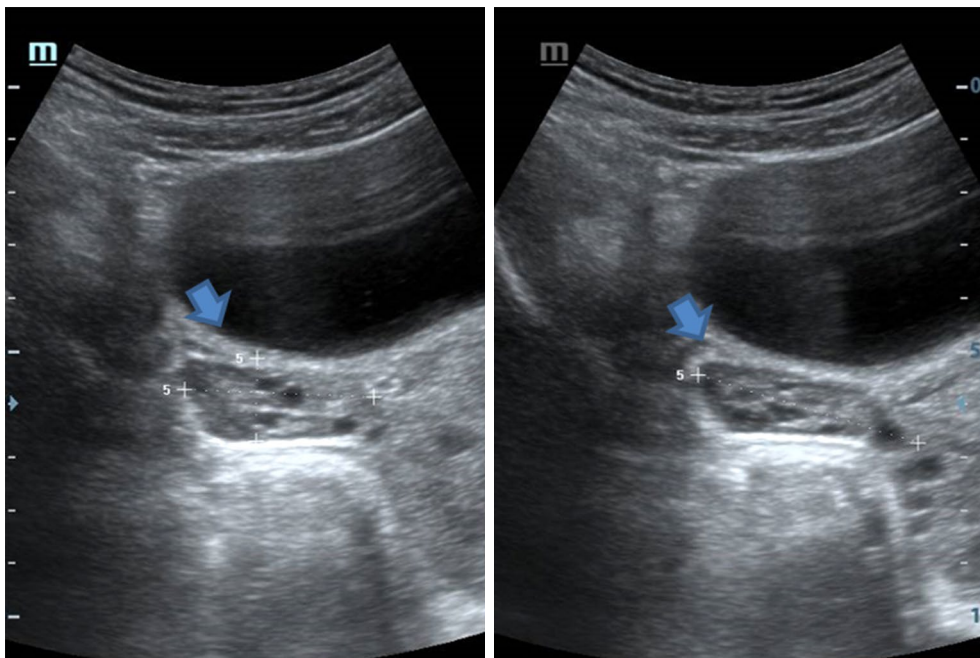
Left ovary with a multifollicular appearance on ultrasonography (arrow: ovarian structure).
